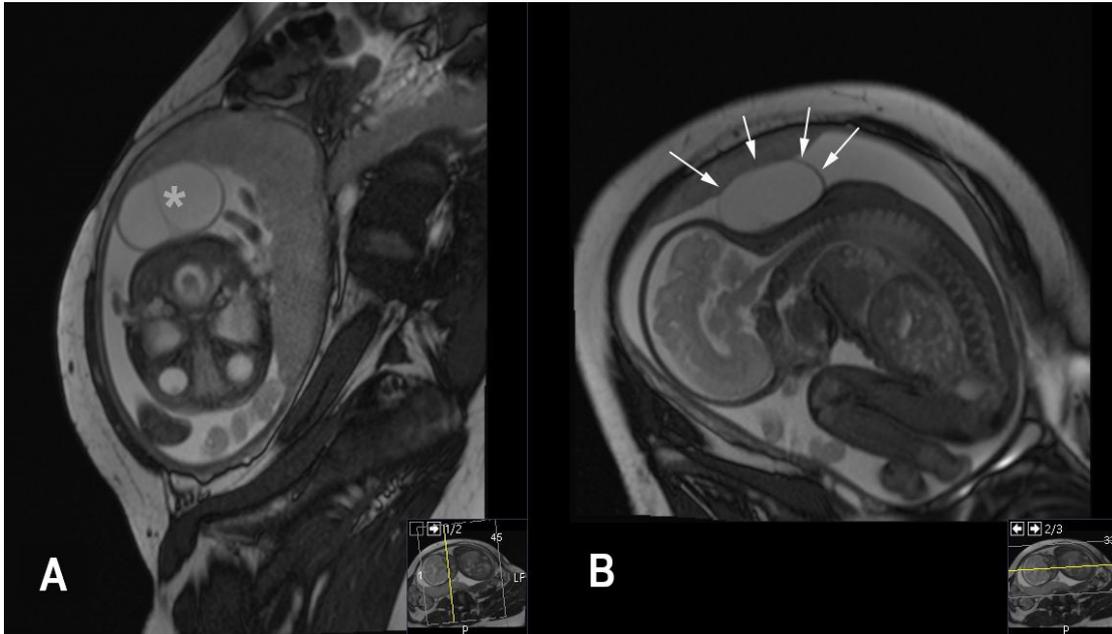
Fetal MRI. A: T2-weighted images, axial sections, The meningocele sac (Asterix). B: T2-weighted images, sagittal sections, The borders of the meningocele sac (Arrow).
